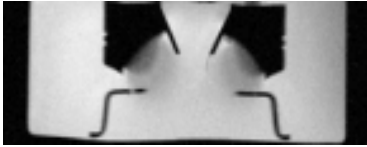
MRI image of the active elements of the probe showing passive MRI compatibility.
